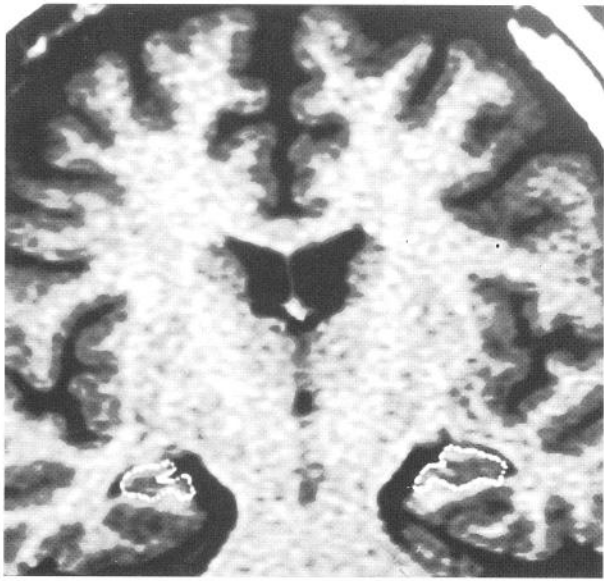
Coronal magnetic resonance imaging scan (Patient 14) passing through the hippocampal bodies showing marked right hippocampal atrophy (ratio = 0.69).
